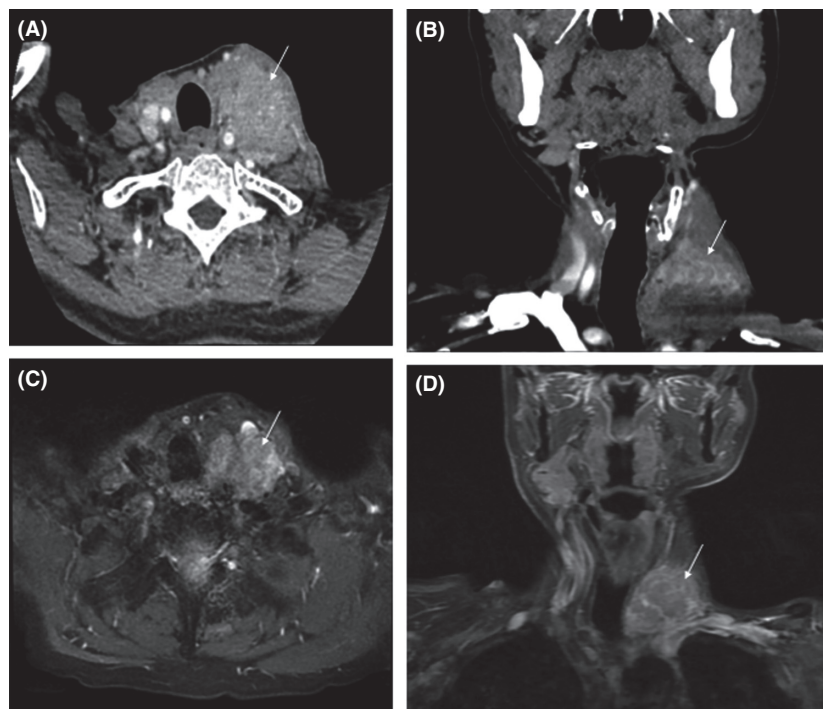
(A–B) Postcontrast CT scan with enlarged lymphadenopathy (white arrow) occupying along the left cervical level IV and left supraclavicular region. (C–D) After three cycles of cisplatin and etoposide, postgadolinium axial and coronal T1FS shows further decreased size of the enhancing lymphadenopathy (white arrow).
